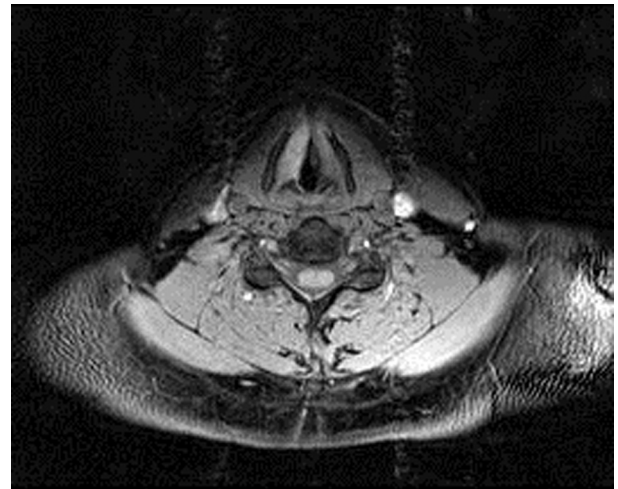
MRI GRE precontrast of the true vocal folds.
